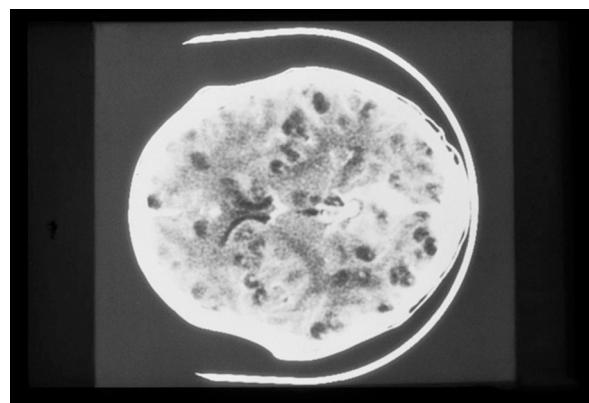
Computed tomography of the head revealing multiple lucencies throughout the cerebral parenchyma representing cysts in a patient with neurocysticercosis. (Courtesy of the American Society of Tropical Medicine and Hygiene.)
